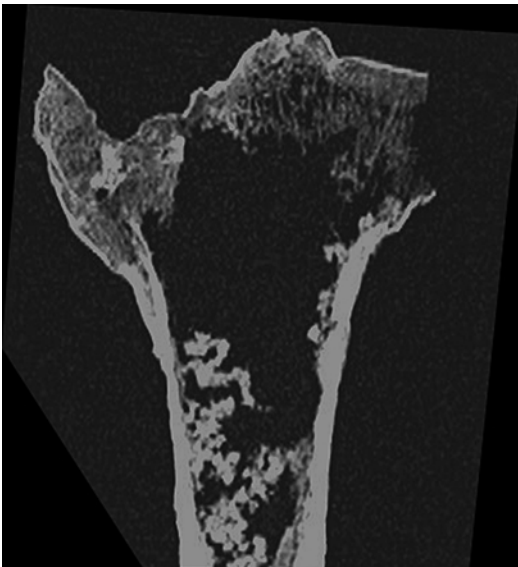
CT scan coronal plane multiplanar reconstruction
